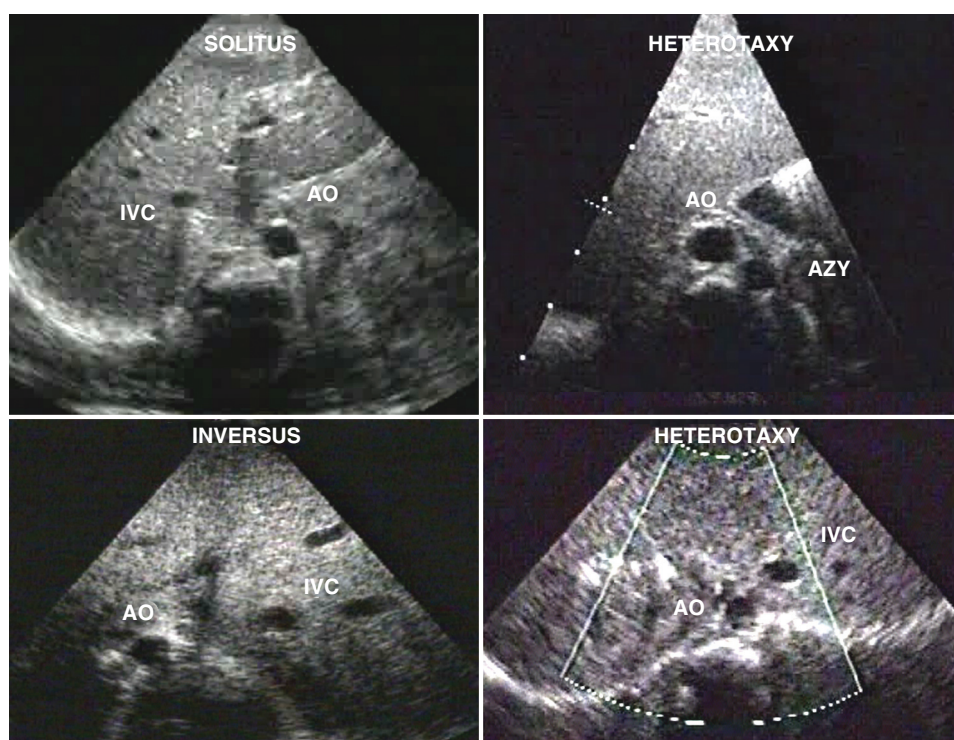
Montage of the different types of situs as seen on a subcostal echocardiographic scan. Note that situs solitus and inversus are just the mirror image of each other. The upper right picture is in the setting of heterotaxy with an interrupted intrahepatic inferior vena cava (IVC) and azygos (AZY) continuation on the *left*. This is seen more frequently with left atrial isomerism. The lower right picture is also in the setting of heterotaxy with an intrahepatic IVC that is positioned closer to the aorta (AO) than in solitus or inversus. Note also the midline liver. This pattern is seen more commonly in right atrial isomerism.
